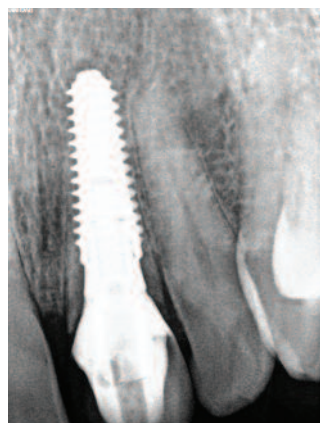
Periapical view of the implant & crown 21.
